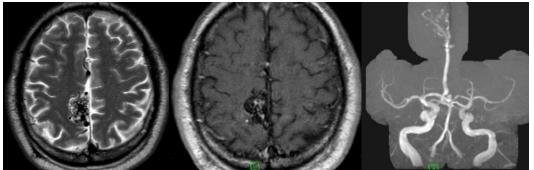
33 year old male with clnical history of epilepsy and severe headache had MRI and MRA study. Cluster of serpiginous flow voids on axial T2W and postcontrast axial T1 MRI in the right parafalcine high parietal region with mild contrast enhancement, suggestive of arteriovenous malformation (AVM). AV malformation with a feeding artery from the right anterior cerebral artery, seen on MRA and draining veins into the superior sagittal sinus.
